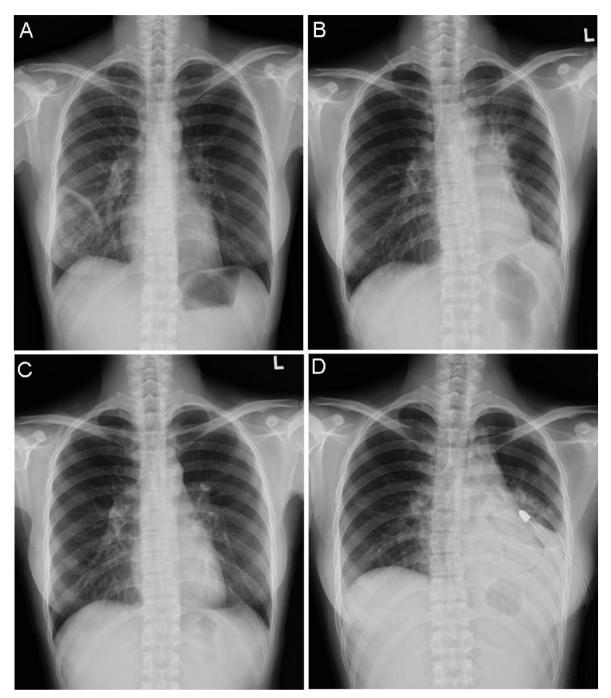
(A) Chest radiograph on initial presentation showed a linear opacity in the right lower lung field. (B) Chest radiograph 4 months later showed partial atelectasis of the left upper lung. (C) Chest radiograph 6 months later showed spontaneous resolution of the pulmonary opacity. (D) Chest radiograph 9 months later showed pneumothorax status post-tubal thoracostomy.
